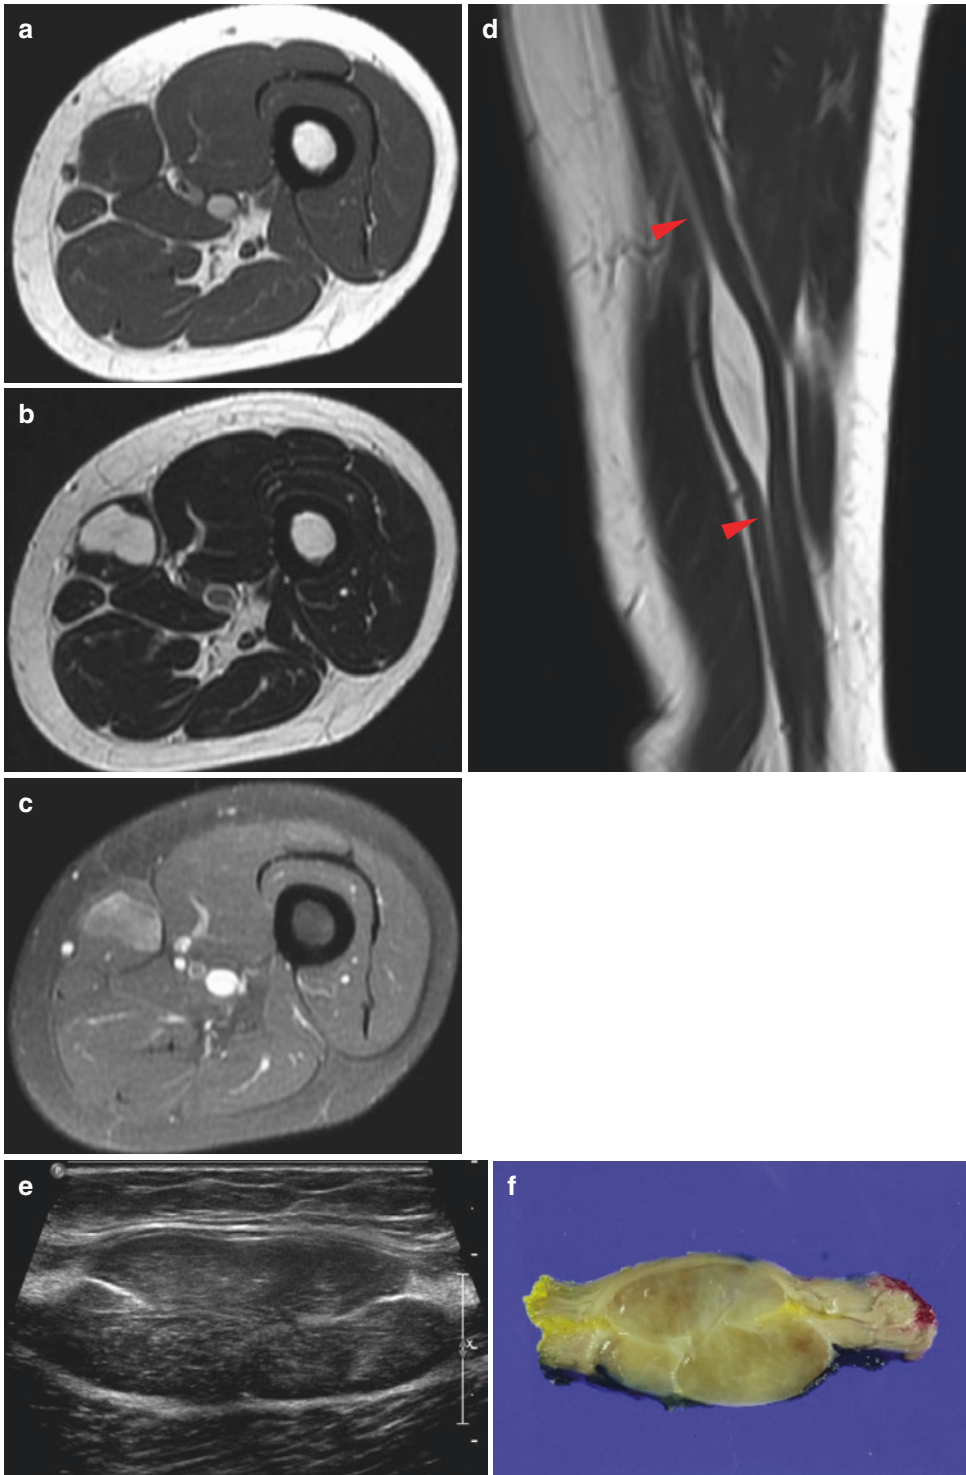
Neurofibroma. MR images of the thigh reveal a circumscribed fusiform mass within the sartorius muscle. The tumor is isointense to muscle on T1WI (a) and hyperintense on T2WI (b), with fuzzy inhomogeneous enhancement on postcontrast FS T1WI (c). Sagittal T2WI
